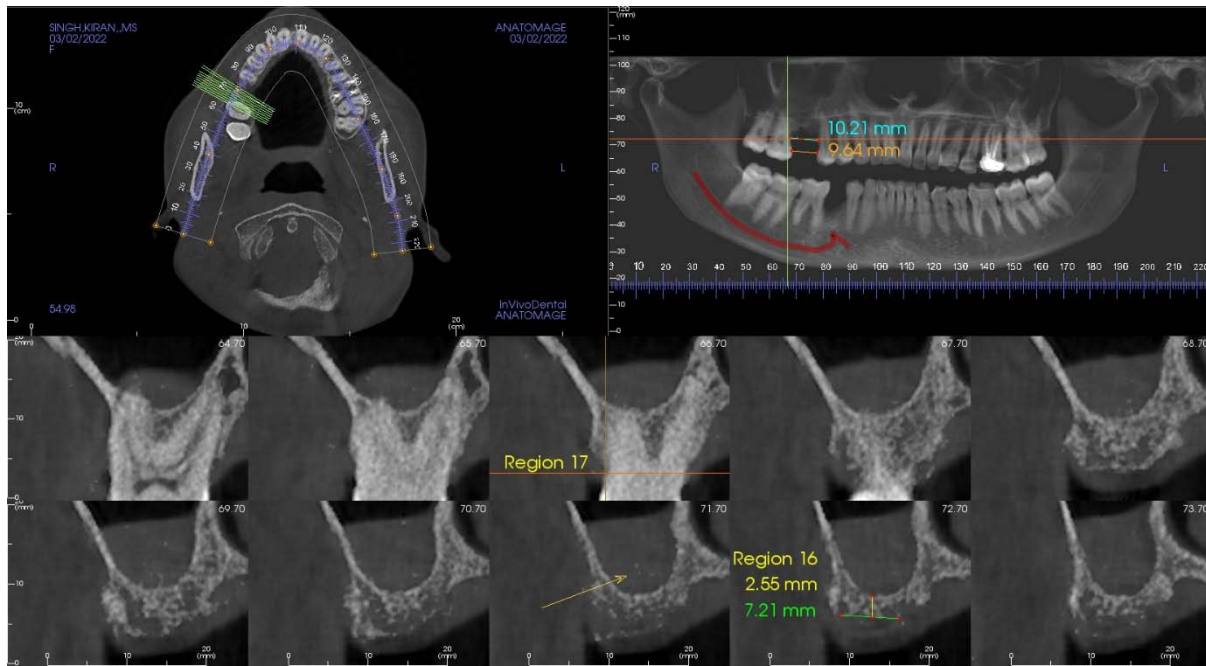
CBCT revealing the readings for the edentulous site
